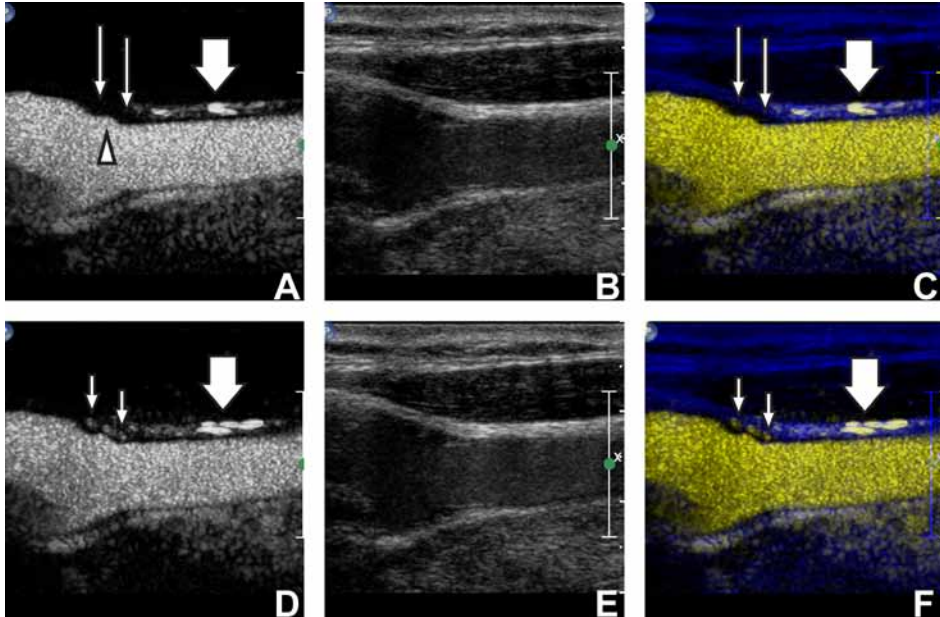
Evaluation of vascular wall irregularities and intraplaque neovascularization by contrast-enhanced ultrasound (CEUS). Carotid artery ultrasound scan performed in the side-by-side contrast mode, acquiring the contrast only images (A and D) and B-mode images (B and E) at the same time. C and F, present an overlay image of both the contrast (yellow) and the B-mode (blue) images, allowing for better delineation of the plaque. In the contrast-enhanced image (A) a small noncalcified plaque of 1.5 mm thick is present in the near wall, proximally to the carotid bifurcation (long thin arrows), which is barely noticeable on the B-mode image (B). In the overlay image (C), a void can be observed between the lumen contrast and vessel wall. The luminal plaque surface appears irregular and is probably ulcerated (arrowhead). The bright regions outside the vessel lumen (thick arrows) are saturation artifacts caused by high scattering regions and are constantly present during the examination. Lower panels: approximately 10 seconds after contrast has reached the carotid lumen, the contrast microbubbles have entered the atherosclerotic plaque indicating intraplaque neovascularization (D and F, small arrows). (Images acquired with a Philips iU22 ultrasound system with a L9-3 probe, SonoVue contrast agent injected intravenously in boluses of 0.5 to 1.0 mL).
